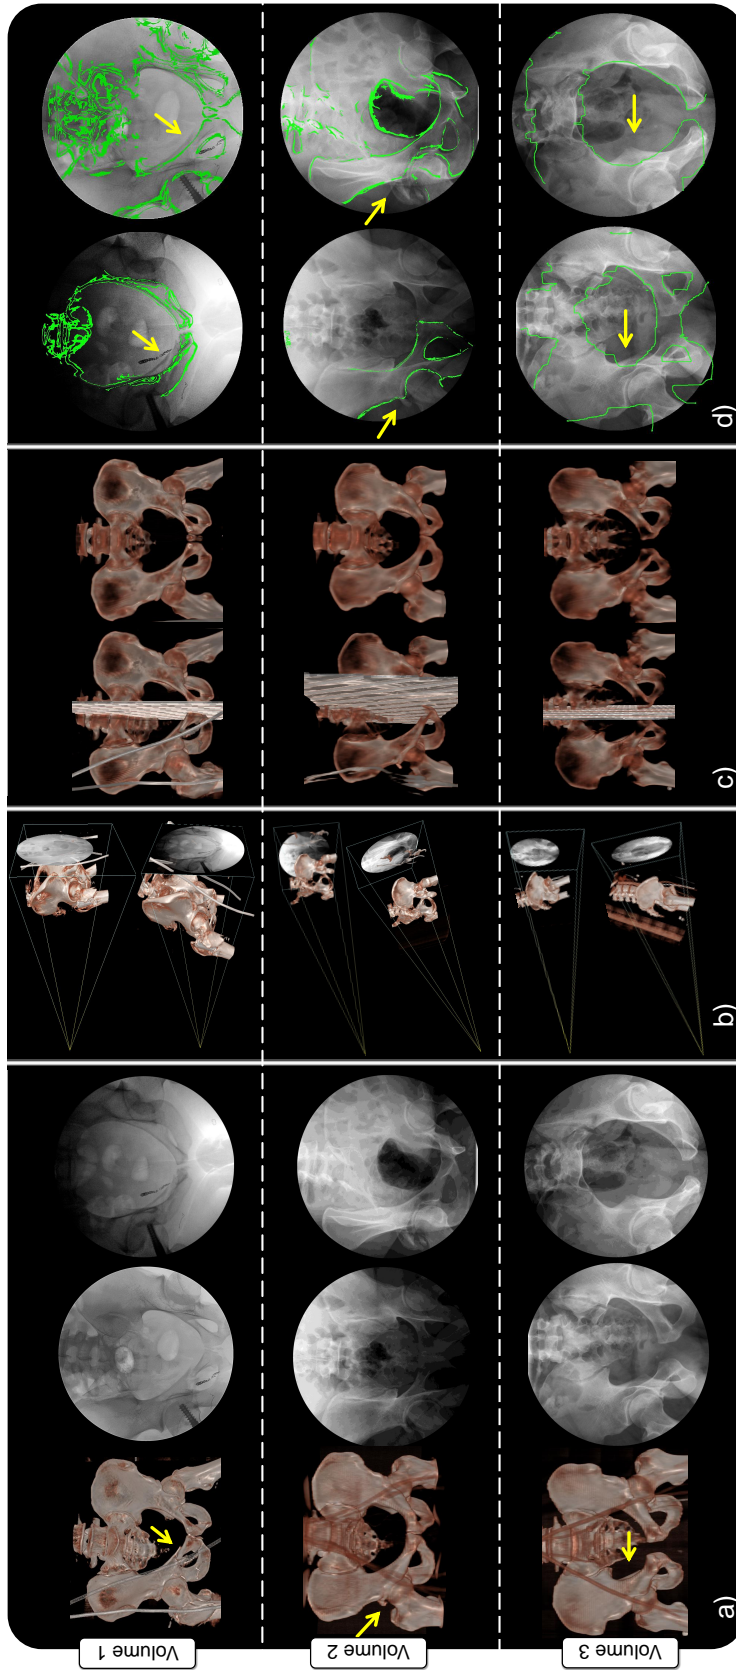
Partial symmetry was exploited to augmented X-ray images with desired configurations of bone fragments. Three cases with severe trauma injuries were investigated here. The first case had displaced pelvic ring fracture, the second case had displaced fracture of the right acetabular roof and the posterior wall, and the third case exhibited asymmetric widening of the left sacroiliac joint. The yellow arrows indicate the fracture location in the figure. We present results given the pre-operative CT as well as two X-ray images (a) for each patient. The relation of each X-ray image was estimated with respect to patient CT (b). As shown in (c), the plane of symmetry was detected and symmetric patient-specific template was generated for each case. Finally, DRRs were generated from the symmetric template and were augmented onto patient X-ray as bone outlines.
